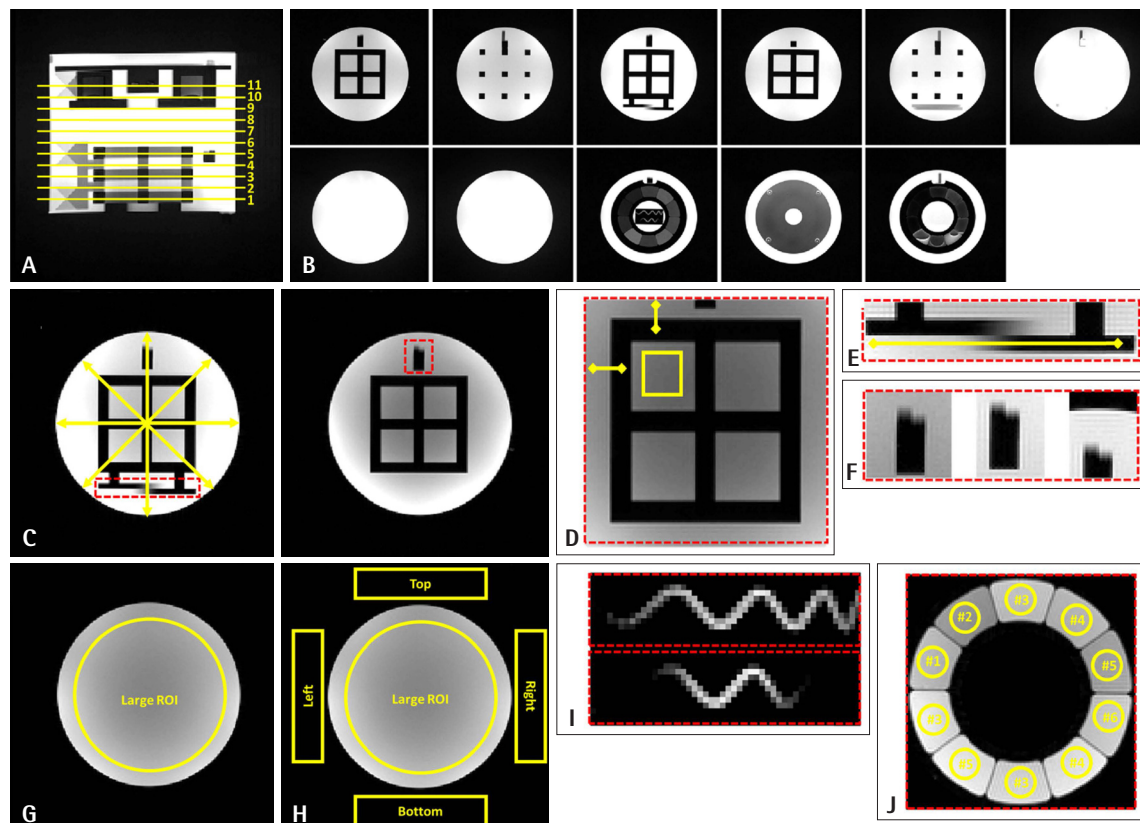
Evaluation of quality assurance for magnetic resonance imaging. A: Sagittal magnetic resonance (MR) image showing the 11 required axial slice locations. B: Axial MR images obtained for each location. C: Magnified MR images of structures for evaluating the geometric accuracy using measurement along multiple yellow double headed arrows. The red dotted square box is used for slice thickness accuracy and the magnified image is shown in Fig. 2E. D: Magnified MR images of structures for evaluating the high-contrast spatial resolution and low-contrast object detectability; the yellow double headed arrows represent the two lines along horizontal and vertical directions for which line spread functions (LSFs) are measured and noise level is measured in yellow box. E: Magnified structure for the slice thickness accuracy measurement; representing the differentiation of the slice profile along the yellow line. F: Magnified structure for the slice position accuracy measurement. G: Measurement of the percent-signal ghosting and signal-to-noise ratio inside the large circular yellow region of interest (ROI). H: Measurement of the image intensity uniformity inside the large circular yellow ROI using the background noise of four square yellow box. I: Magnified structure for the vessel conspicuity measurement. J: Measurement of the brain tissue contrast inside various compartment represented by yellow ROIs.
